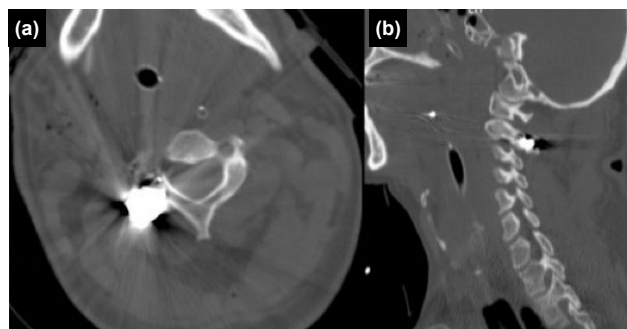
(a, b) Cervical computed tomography (CT) scan showing right facet fractures of the C1 and C2 vertebrae, along with visible metallic artifacts.
